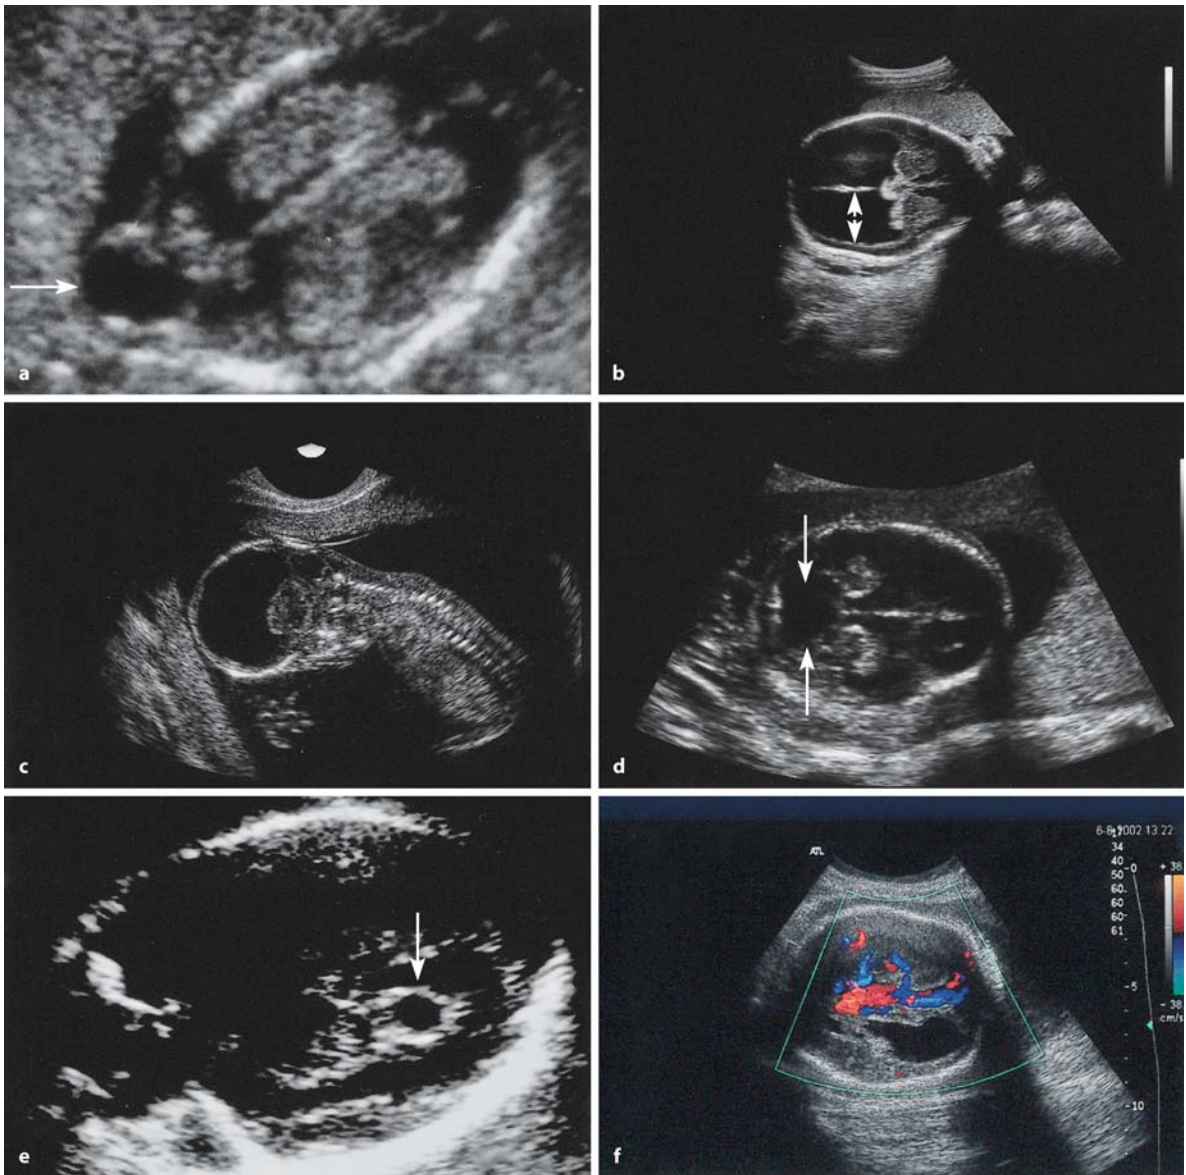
Normal and abnormal ultrasound scans: a 12-week-old fetus with encephalocele (*arrow*); b second-trimester fetus with ventriculomegaly (*arrows*); c fetus with alobar form of holoprosencephaly; d Dandy-Walker malformation (*arrows*;
